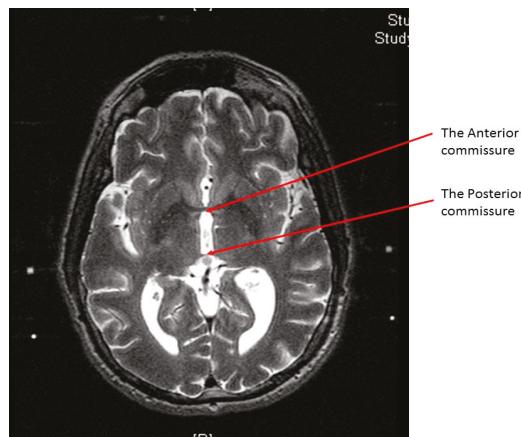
An axial T2 weighted magnetic resonance imaging (MRI) image showing the anterior commissure and the posterior commissure.
